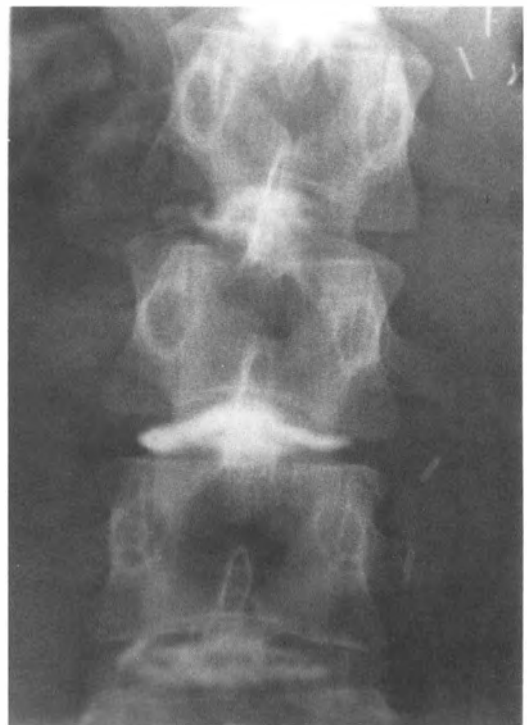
Anteroposterior lumbar spine radiograph.
